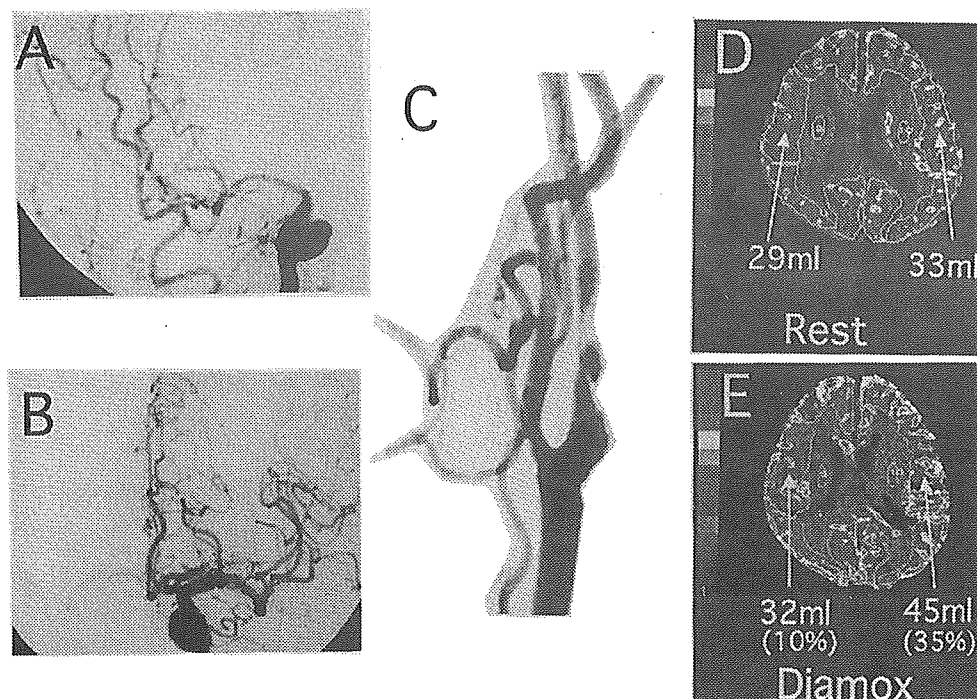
Right carotid angiography shows poor visualization of the right A1 (A). Left carotid angiography demonstrates poor anterior cross circulation (B). Right cervical carotid angiography shows the severe ICA stenosis with deep ulcer (C). Cold Xe-CT's reveal significant decrease in resting cerebral blood flow (D) and poor vasoreactivity (E) on the right hemisphere.
